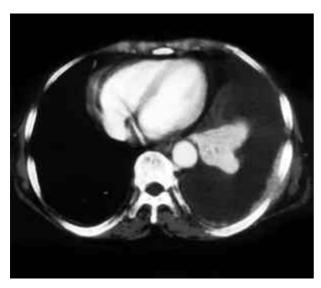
Thoracic CT scan. Contrast-enhanced CT scan shows a posterior pleural-based enhanced mass encasing ribs without bony destruction as well as a large pleural effusion in left lower hemithorax.
